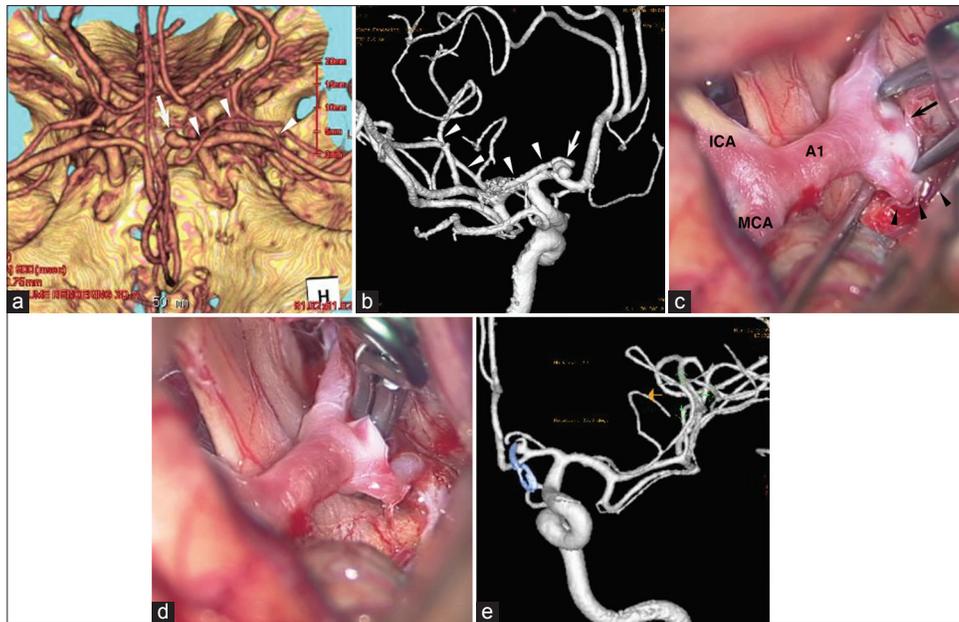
(a) Three-dimensional computed tomography angiography showing an aneurysm (arrow) at the origin of an accessory middle cerebral artery (arrowheads). (b) Angiography demonstrating an aneurysm (arrow) at the junction of A1 of the anterior cerebral artery and accessory middle cerebral artery. The accessory middle cerebral artery (arrowheads) runs laterally along with the middle cerebral artery. (c) An intra-operative photograph showing an aneurysm (arrow) at the origin of the accessory middle cerebral artery (arrowheads). The aneurysm is projecting medially. (d) An intra-operative photograph showing that the aneurysm is clipped. (e) Follow-up angiography obtained 27 months after the operation, showing a small residual neck of the aneurysm
